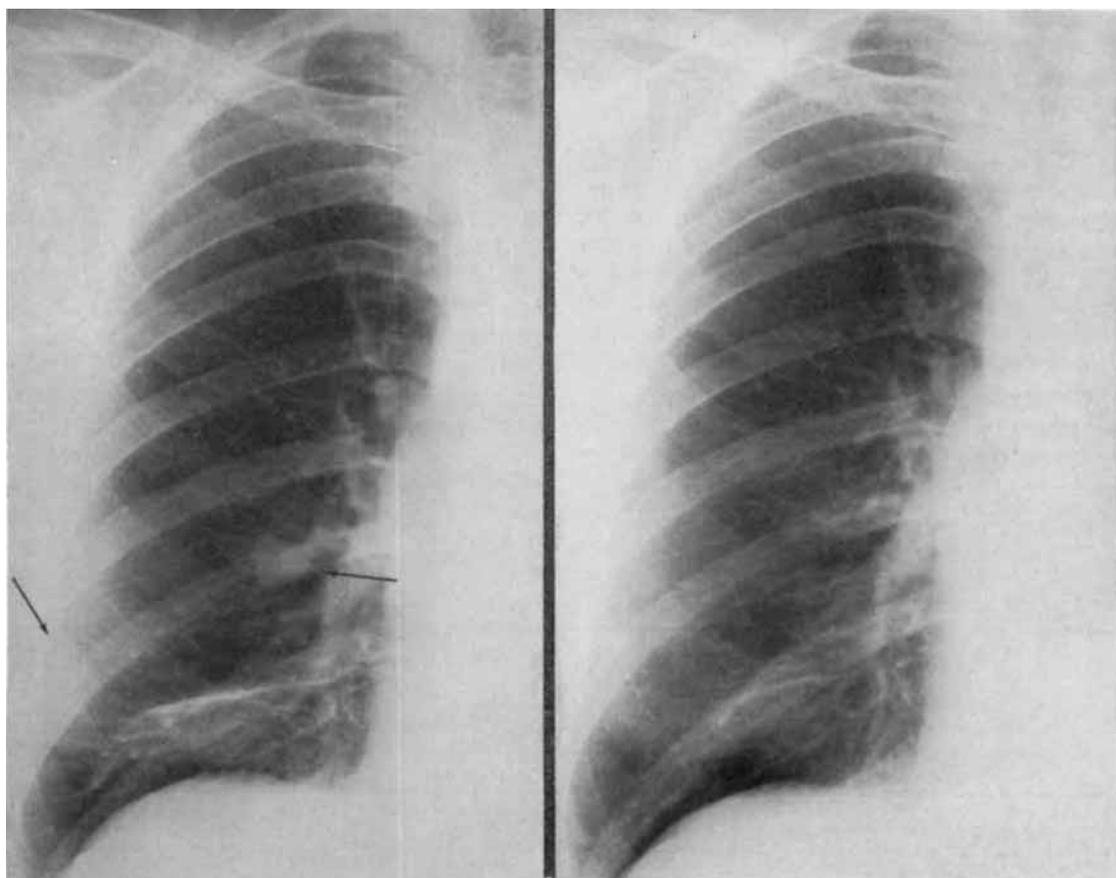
A (left), Pretreatment roentgenogram of right lung of patient JP, showing two metastatic nodules. B (right), After 3 months of intramuscular medroxyprogesterone acetate therapy.
